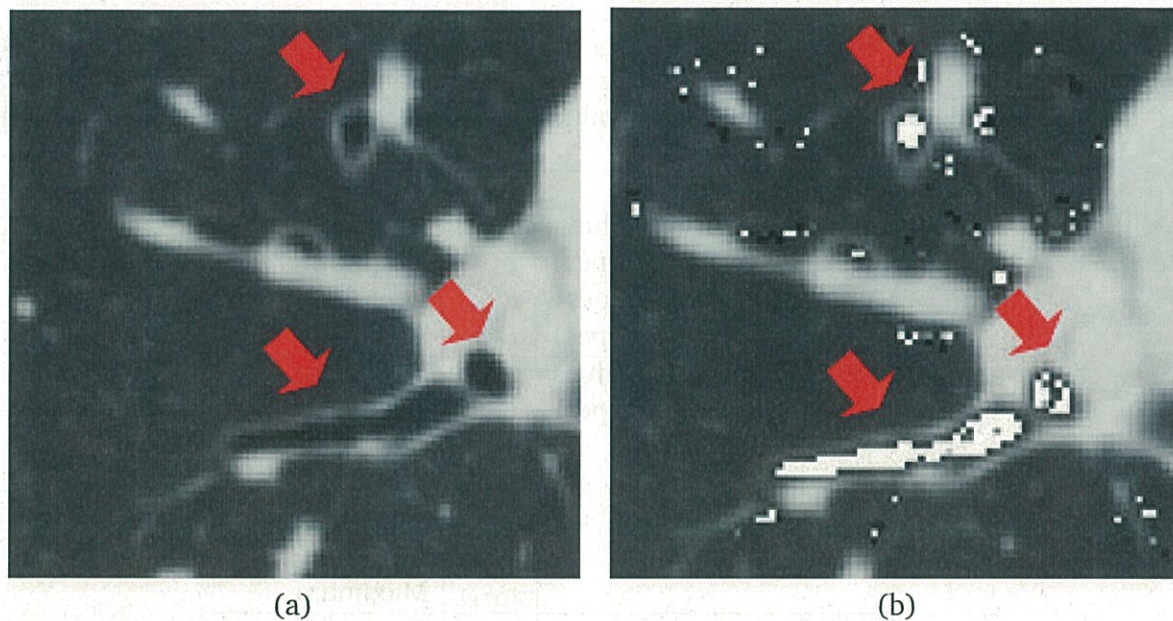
Output of adaptive multiscale CEF for CT image, (a) original CT axial slice with bronchus region (b) CEF output overlapped on CT axial slice. Red arrows indicate the locations of the bronchi. Some black spots appear in (b) due to the low value of the CEF result.
